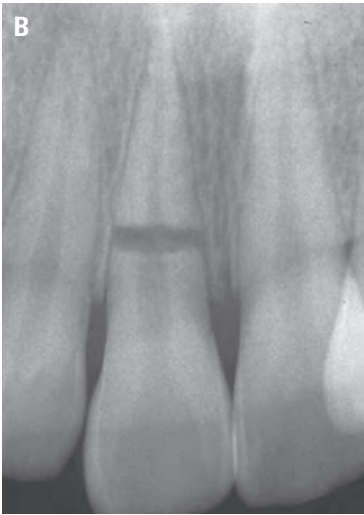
Management of root fractured tooth. A, Clinical photograph shows coronal part of tooth no. 8 displaced in an extrusive direction. B, Radiograph shows location of fracture and separation of the root at the line of fracture. C, Photograph shows the splinting completed after repositioning of the coronal part of the tooth. No root canal treatment was necessary.
